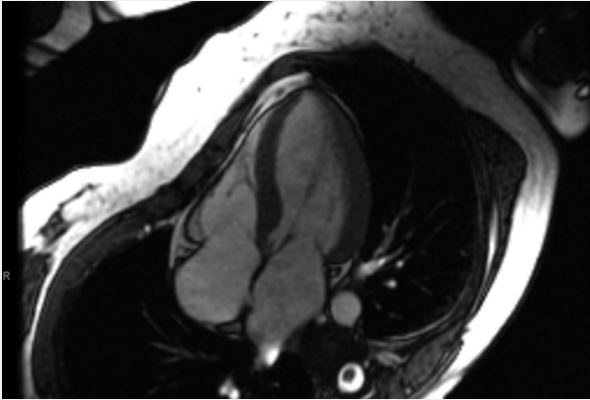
MRI image showing subaortic membrane at the junction of the septal leaflet of the mitral valve and interventricular septum.
